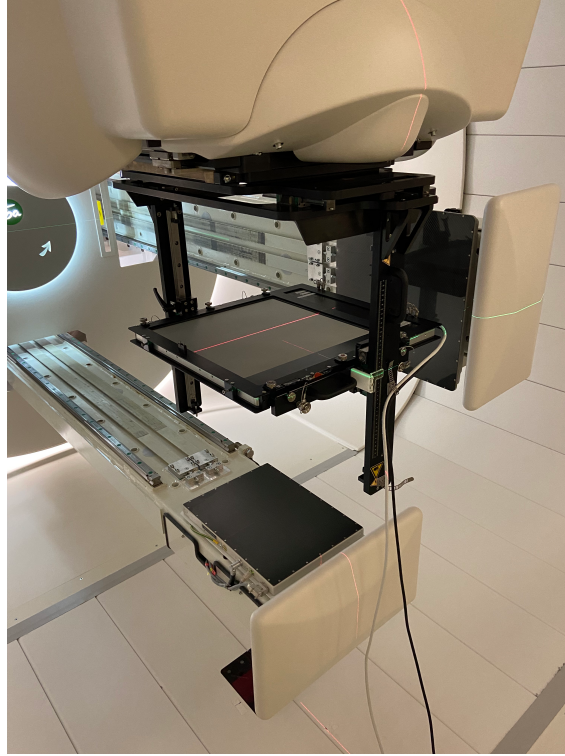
The Phoenix detector is placed on a nozzle holder which is attached to the gantry. The X-ray machine can be observed below and to the right of the detector in the image.
